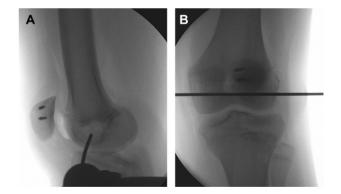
Intraoperative radiographs. (A) Lateral and (B) anteroposterior views of a left knee during femoral socket positioning of medial patellofemoral ligament reconstruction in a skeletally immature patient (12 years of age). (A) Identification and verification of the entry point using a pin on a surface localizing shot. The trajectory of the pin is anterior, strictly extraphyseal. (B) After identification of the entry point, a guide pin is introduced after visualization of the anterior and posterior cruciate ligaments and verification that the structures remain uninjured; a bioabsorbable interference screw is used to secure the graft within the medial condyle distal to the physis. Suture anchors are visible within the patella, facilitating graft fixation.
